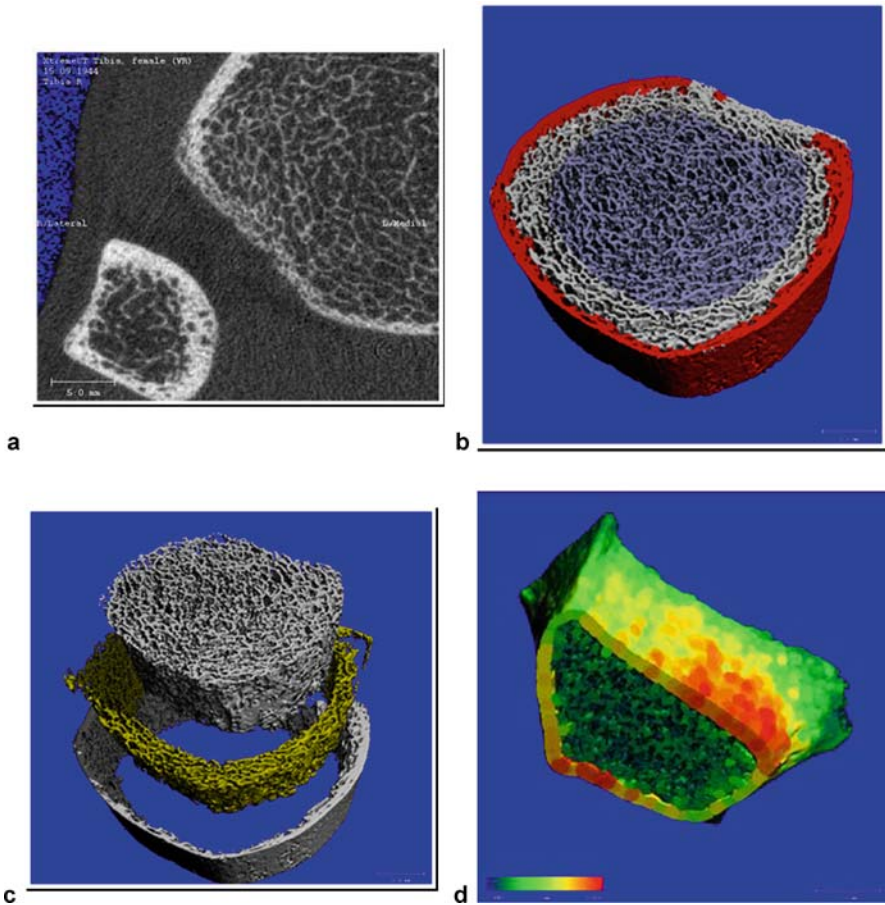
In-vivo Xtreme-CT for human application with 3D reconstructions. a A 2D image of ultradistal radius. b A 3D reconstruction with defined region of interests. c A “cut out” of region of interests defined in b. d A 3D reconstruction of radial cortical shell at distal radial diaphysis
